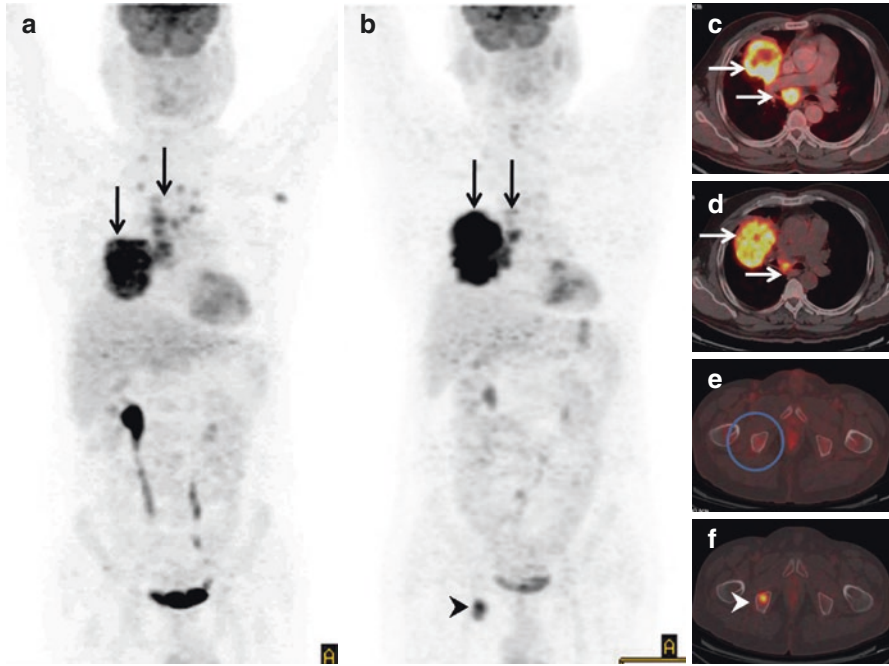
Pre- and post-therapy whole body MIP studies (arrows in a, b) and fusion PET/CT studies (arrows in c, d) show persistent disease at the primary site and mediastinal nodes. Post-therapy whole body MIP study and fusion PET/CT studies (arrowheads in b, f) show a solitary marrow metastases in the ischial tuberosity. Note: Normal-appearing ischial tuberosity in pretreatment PET/CT (circle in e)
